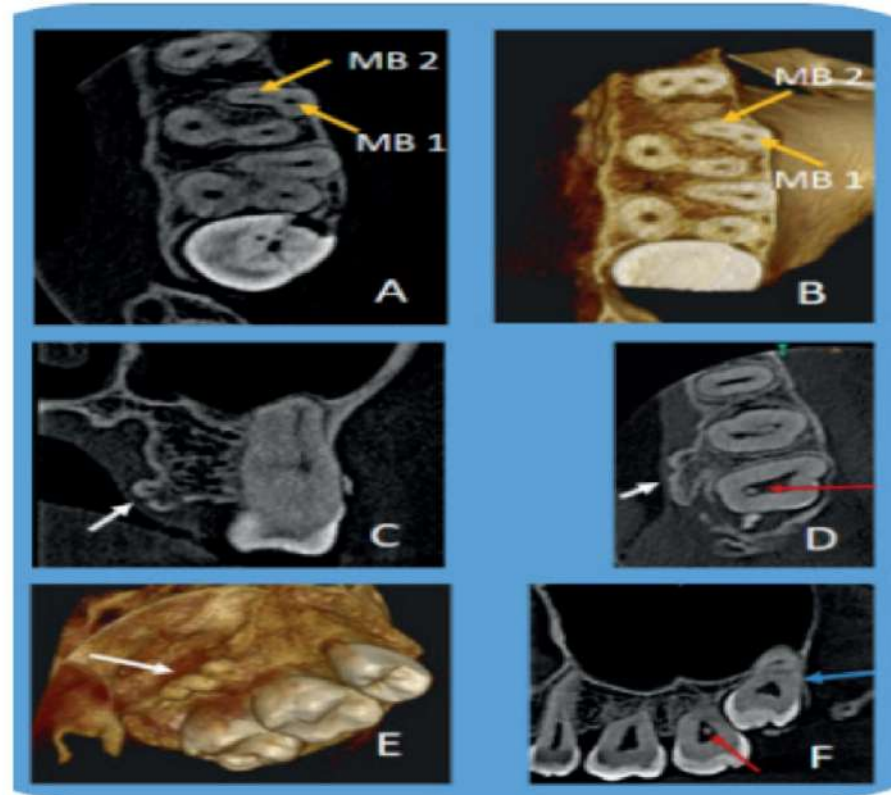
Small FOV, CBCT scan of left posterior maxilla showing MB2 canal in first molar (A, B), exostosis (C,D,E), pulp stone in second molar (D,F), third molar relationship with sinus (F), and the sinus devoid of any pathology.
